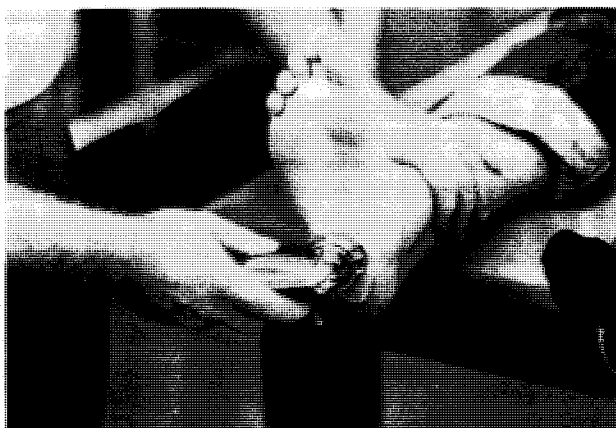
Phonophoretic application of a water-soluble ointment containing dexamethasone and lidocaine for inflammatory condition. The ultrasound soundhead drives medication percutaneously into inflamed structures. (Reproduced with permission from Ref. 6.)
